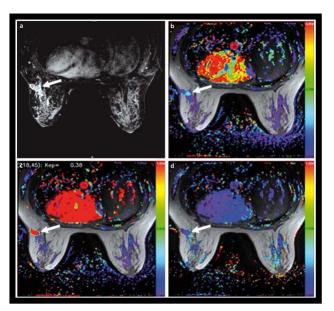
A 43-year-old female with breast cancer. Axial T1W DCE-MR image demonstrates an enhancing lesion in the left breast (arrow) (a). Color-coded <u>Ktrans</u> (b), K_{ep} (c) and V_e (d) maps delineate the tumor (arrows).[6] Courtesy of Turkbey et al, 2010.
